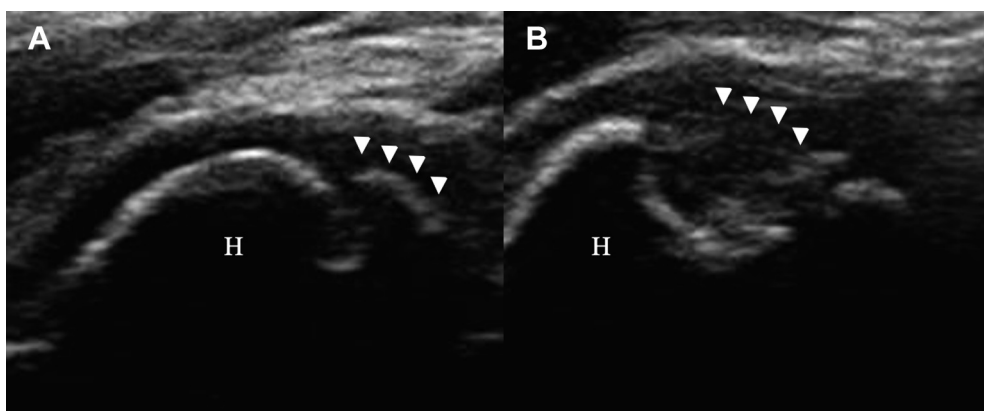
Long-axis view of the elbow by US imaging. (A) Capitellum of the humerus shows osteochondritis dissecans. (B) Comminution of subchondral bone. White arrowheads show lesion locations. US, Ultrasound; H, Humerus.
